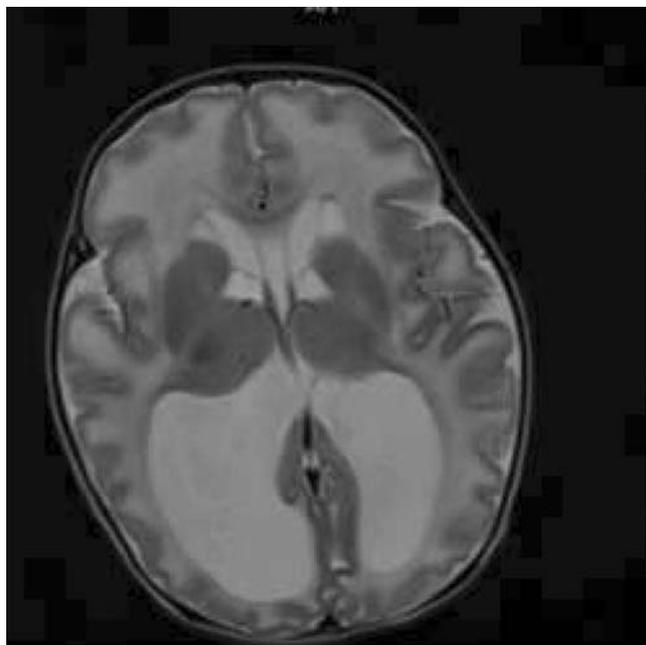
MRI brain of patient showing Bilateral periventricular and subependymal cysts in the caudothalamic groove and dilated lateral ventricles).
